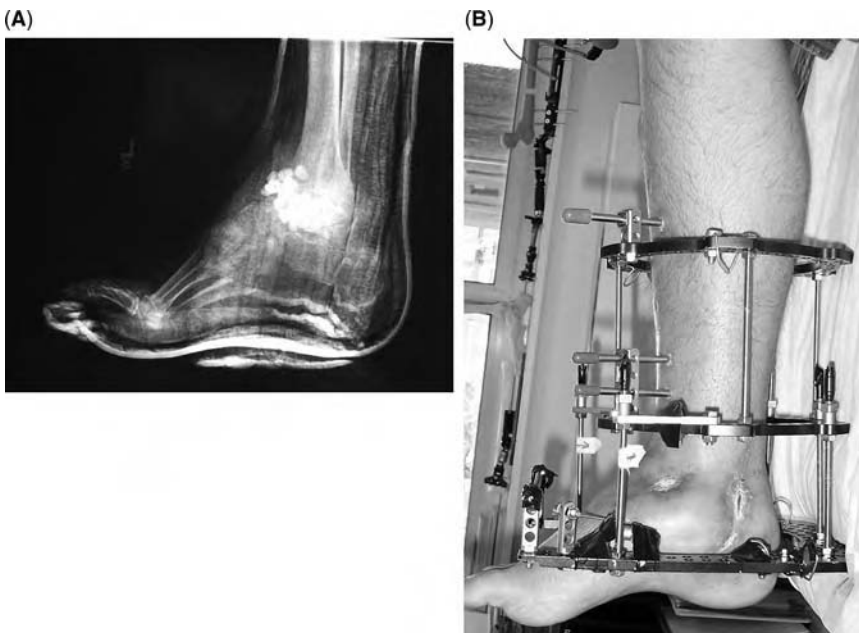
(A) Lateral X-ray showing antibiotic beads in defect after resection of the talus. This patient had septic osteonecrosis of the talus requiring resection. (B) Side view of the ankle arthrodesis frame applied after removal of the beads and preparation of the tibia and calcaneus for fusion. Gradual leg shortening was done and leg length discrepancy was treated by adjusting a contralateral amputation prosthesis.
